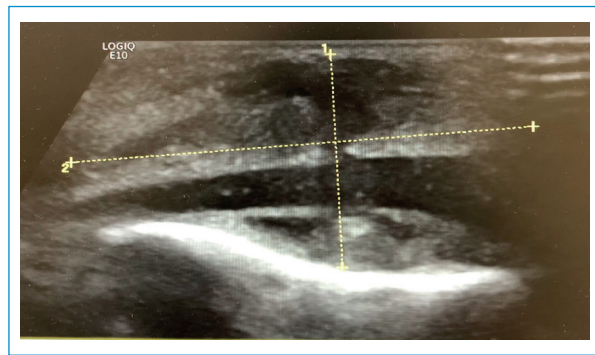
Case 3: ultrasound of sternal lesion with dumbbell-shaped subcutaneous lesion.
